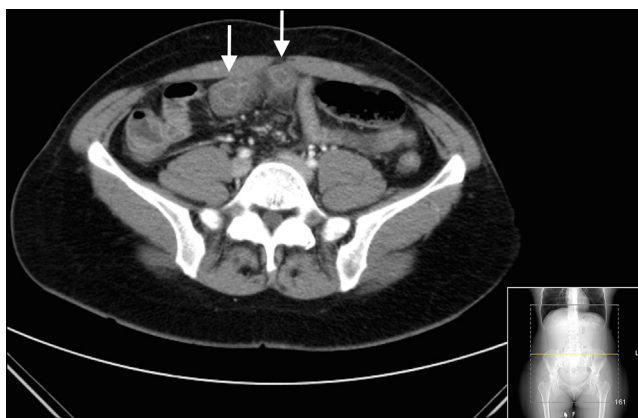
Contrast-enhanced computed tomography demonstrating circumferential transmural thickening of ileum walls, producing a target-like lesion (arrows) that is typical of edema.
